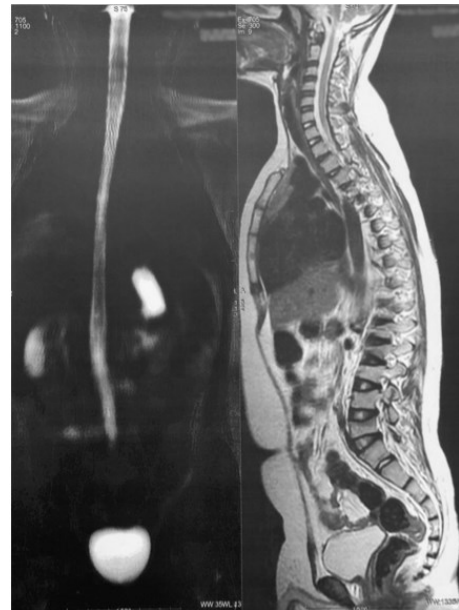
MRI and myelography of spine
